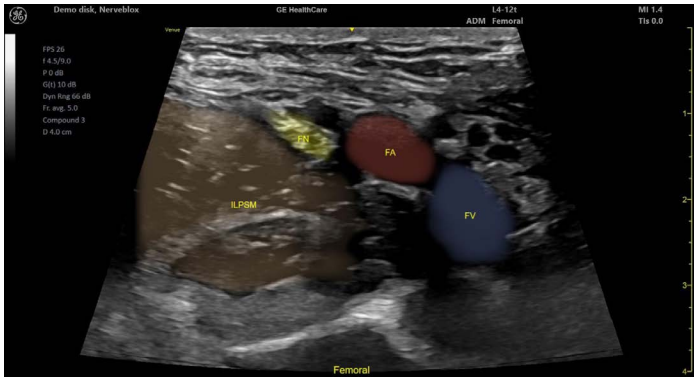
Ultrasound image of femoral nerve block.
